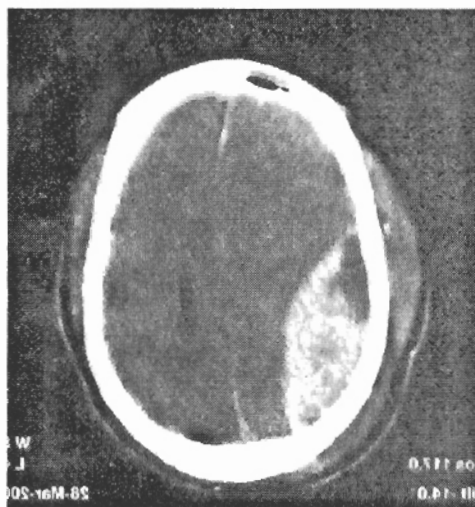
CT appearance of a right subdural haematoma
